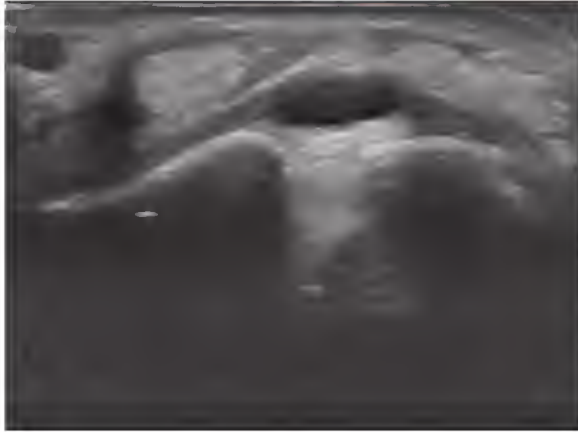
e69.11 Transverse ultrasound image of a scapholunate ganglion.
